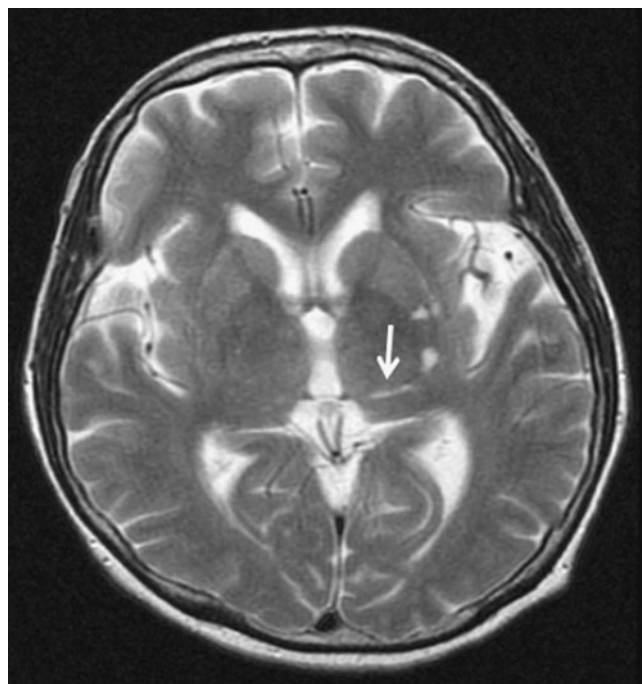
T2-weighted brain magnetic resonance image of the patient shows an old infarction in the left thalamus (arrow) and some ischemic lesions in the left putamen.
